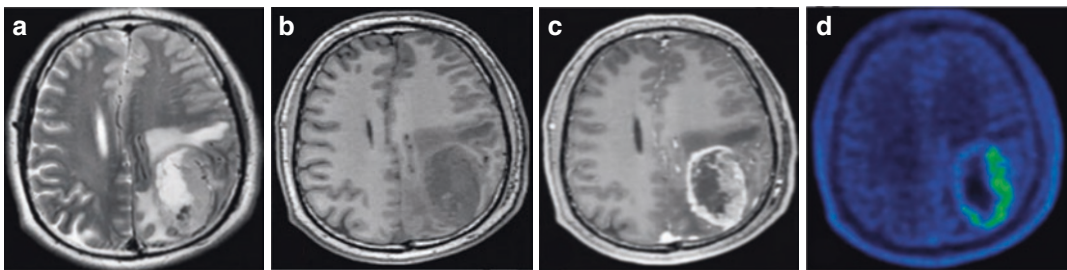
Left parietal lobe glioblastoma, WHO grade IV. A 41-year-old male patient whose MRI shows an oval mass in the left parietal lobe. Transverse T₂WI shows heterogeneous mixed isointense and hyperintense signals (a); transverse T₁WI shows hypointense signals surrounded by
